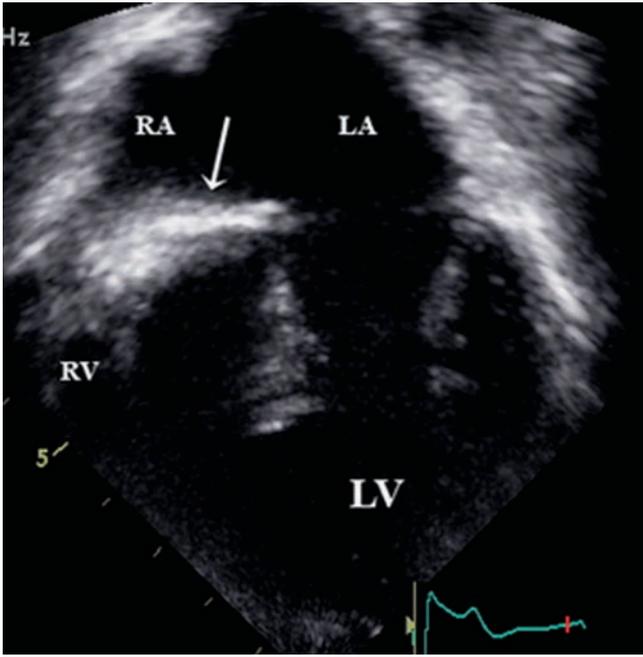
Tricuspid atresia. Apical 4-chamber view in patient with absent right atrio-ventricular connection (tricuspid atresia). The absent right atrio-ventricular connection is seen echocardiographically as an echogenic border between the right atrium and small right ventricle (*arrow*). The atrial communication between the right (RA) and left atria (LA) is widely patent. The mitral valve and left ventricle (LV) dominate the image. The right ventricle (RV) is barely seen in this image
